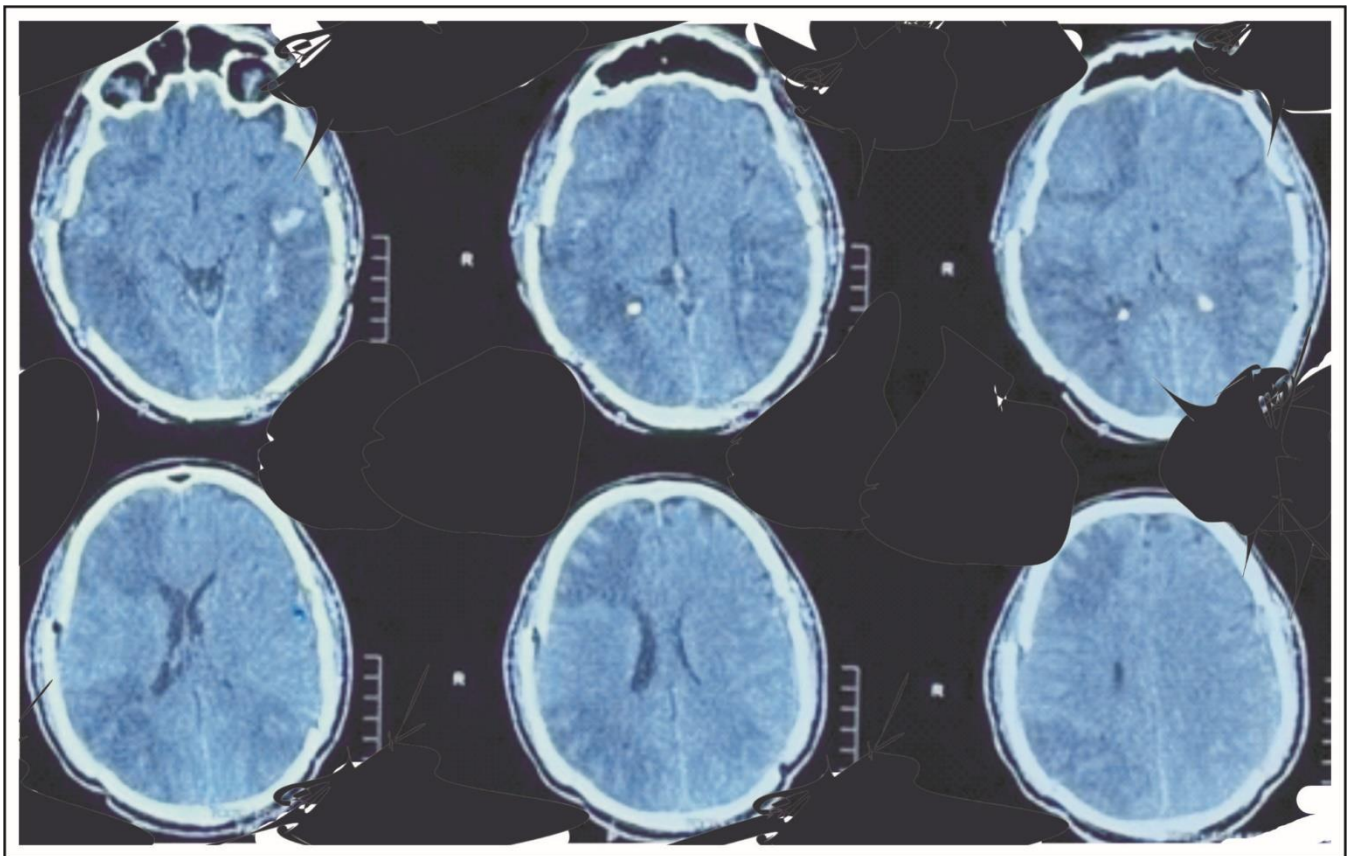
CT scan after second surgery (Presented with patient's consent).
